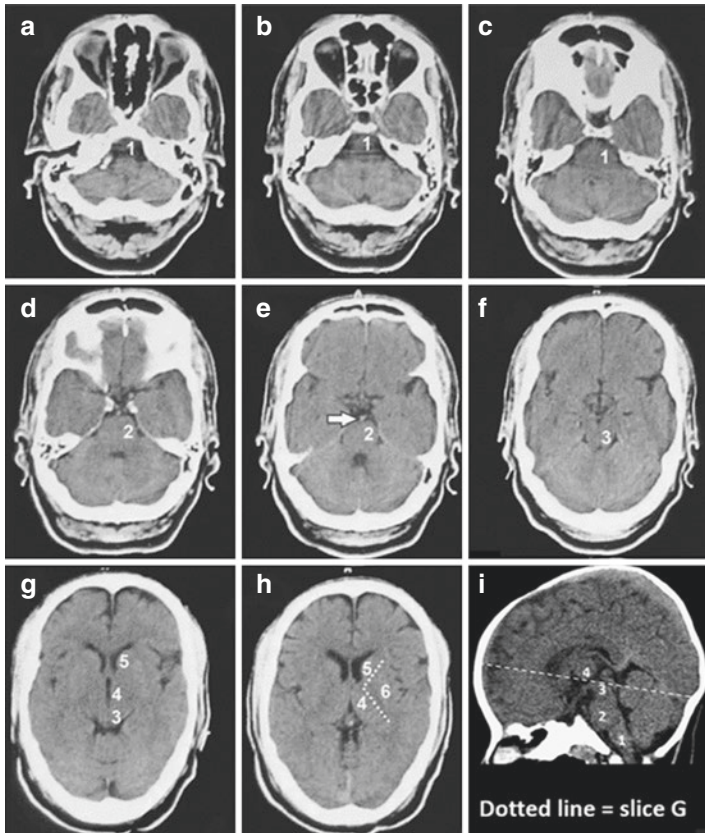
Non-contrast CT scan showing landmark structures numbered from 1 to 6 and the individual axial images are labeled from a to h and one sagittal image labelled i
